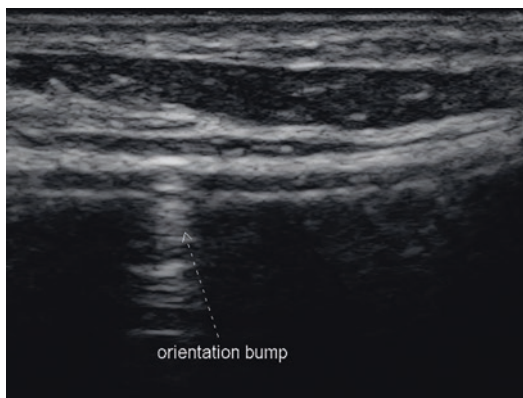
Grayscale ultrasound image of a shaped Allergan 410 silicone gel breast showing the orientation bump on the surface of the elastomer. Posterior acoustic shadowing is seen below the echogenic line indicating the location of the palpable bump
